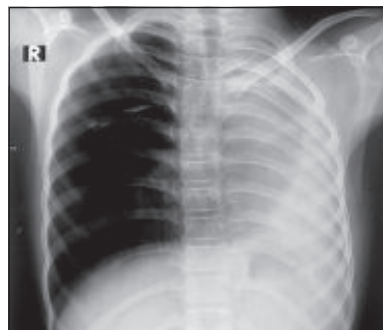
Pulmonary aplasia: X-Ray Chest showing complete opacification of the left hemithorax with marked volume loss. Over expanded right lung is seen herniating across the mid line into the left hemi-thorax. Marked chest asymmetry is quite evident.*
